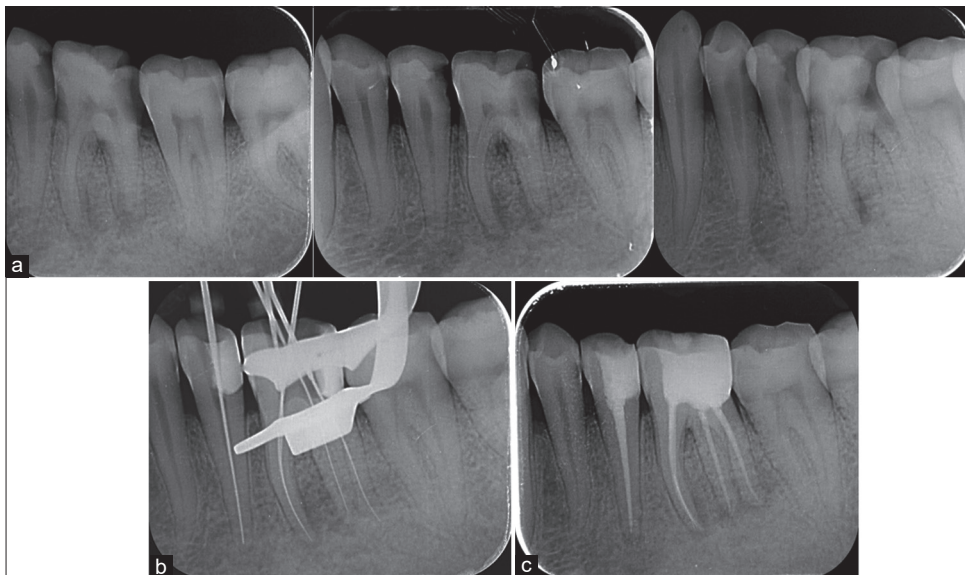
(a) Pre-operative radiograph with different horizontal radiograph (b) working length (c) obturation and post-endodontic restoration
